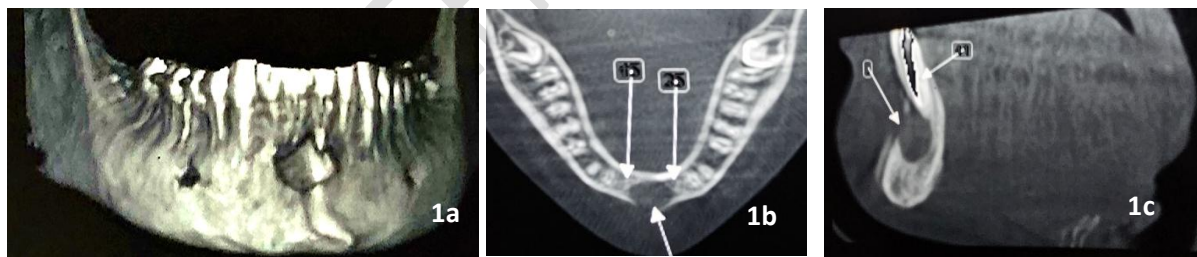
CBCT preoperative 3D view of the lesion in relation to the periapical region of root canal treated 31 and 41, 1b: axial view, 1c: sagittal view
